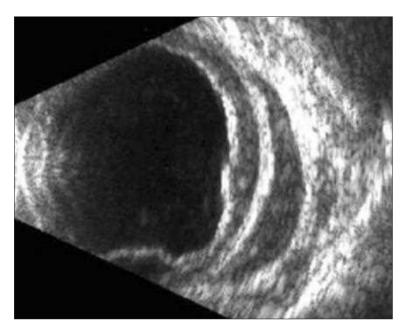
B-Scan Ultrasound Image of an Eye With Diffuse Uveal Lymphoma Showing Generalized Choroidal Thickening and a Hypoechoic, Crescentic, Retroscleral Accumulation of Tumor Cells.
